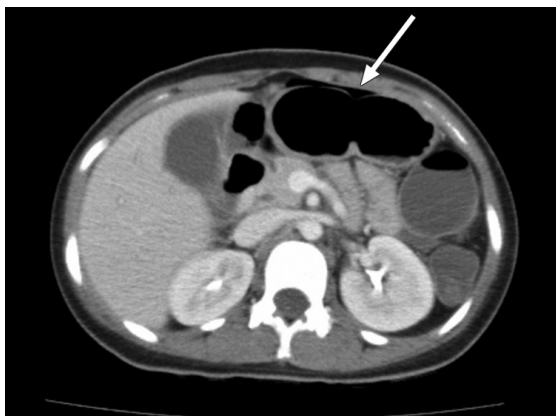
CT image shows bowel wall-thickening, with a sliver of extraluminal air visible (arrow).
